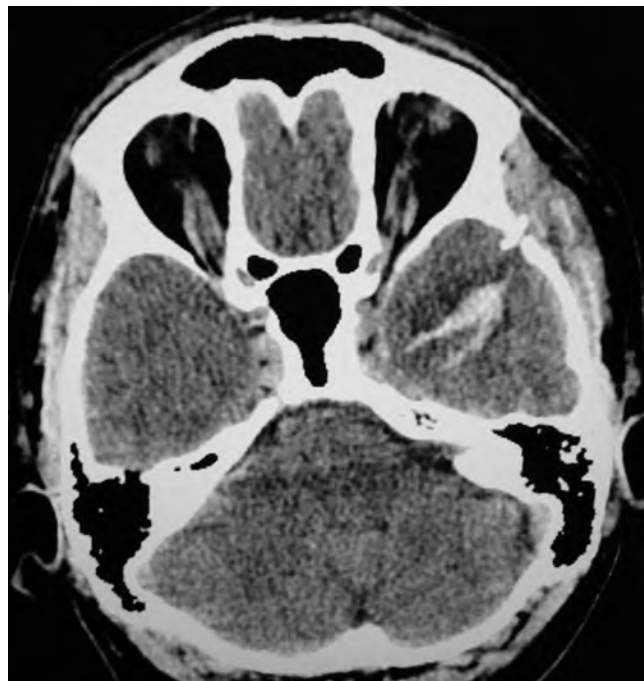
Non-contrasted cranial CT scan showing left squamous bone temporal fracture and hyperdense linear lesion traversing left temporal lobe parenchyma.
